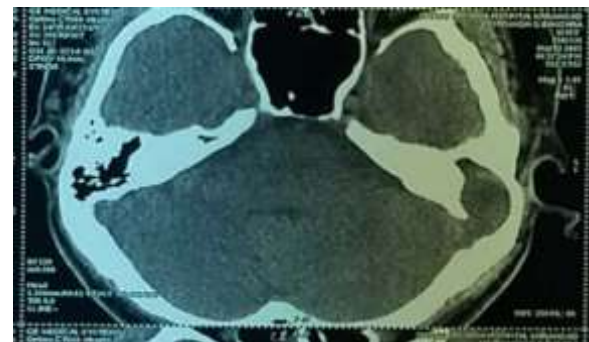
HRCT scan showing sigmoid sinus erosion.
